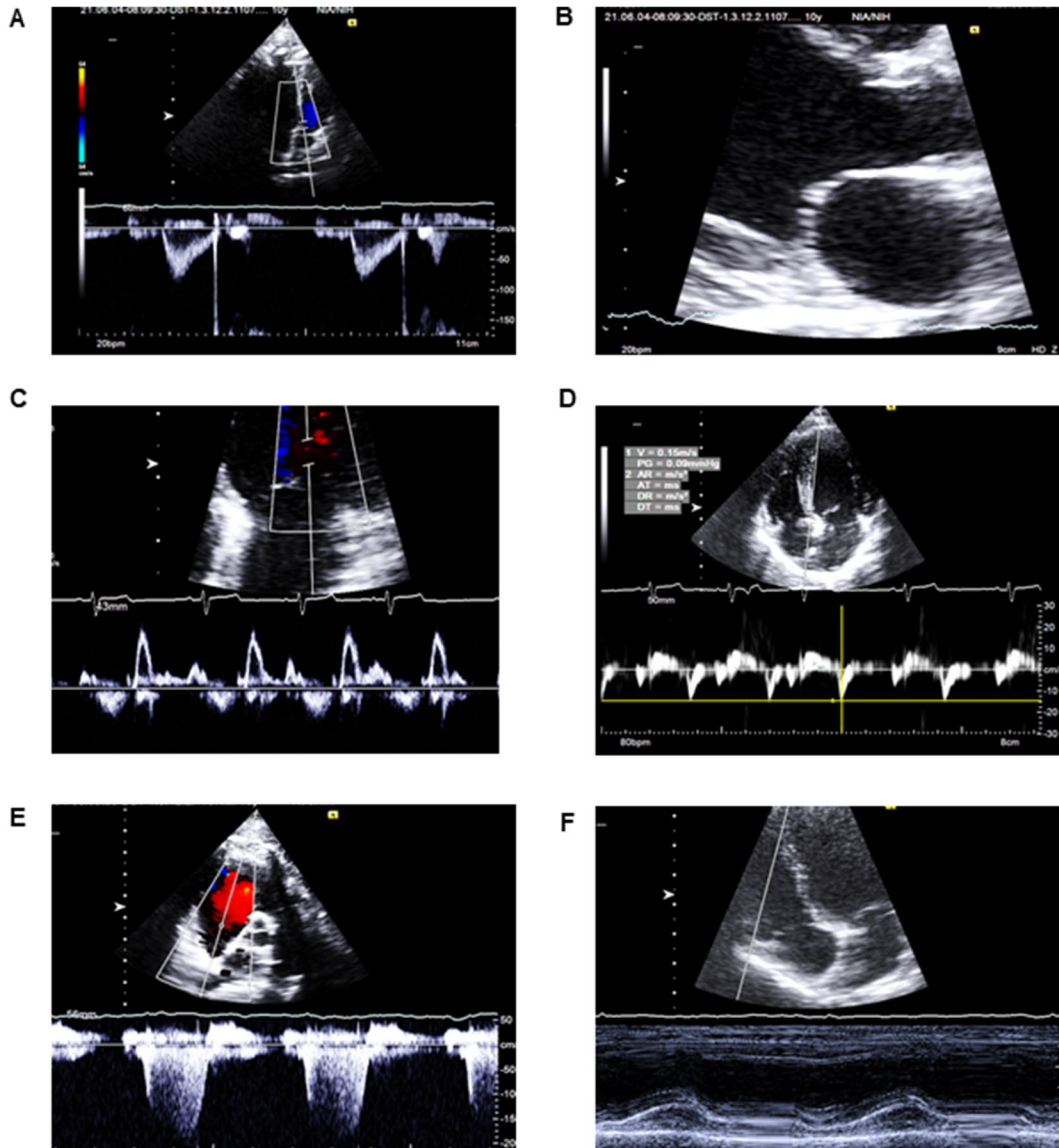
Comprehensive noninvasive hemodynamic assessment by 2D TTE, M mode, and Doppler. A Pulsed wave Doppler of the LV outflow tract. B Measurement of the LVOT diameter. C Mitral inflow pattern. D Tissue Doppler E' wave of the basal
